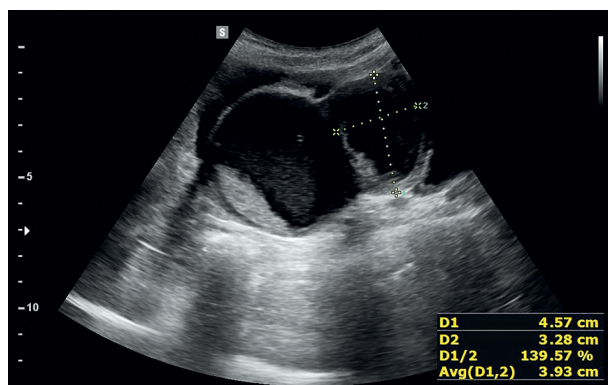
Ultrasonography of cystic lesions localized in the lesser pelvis
